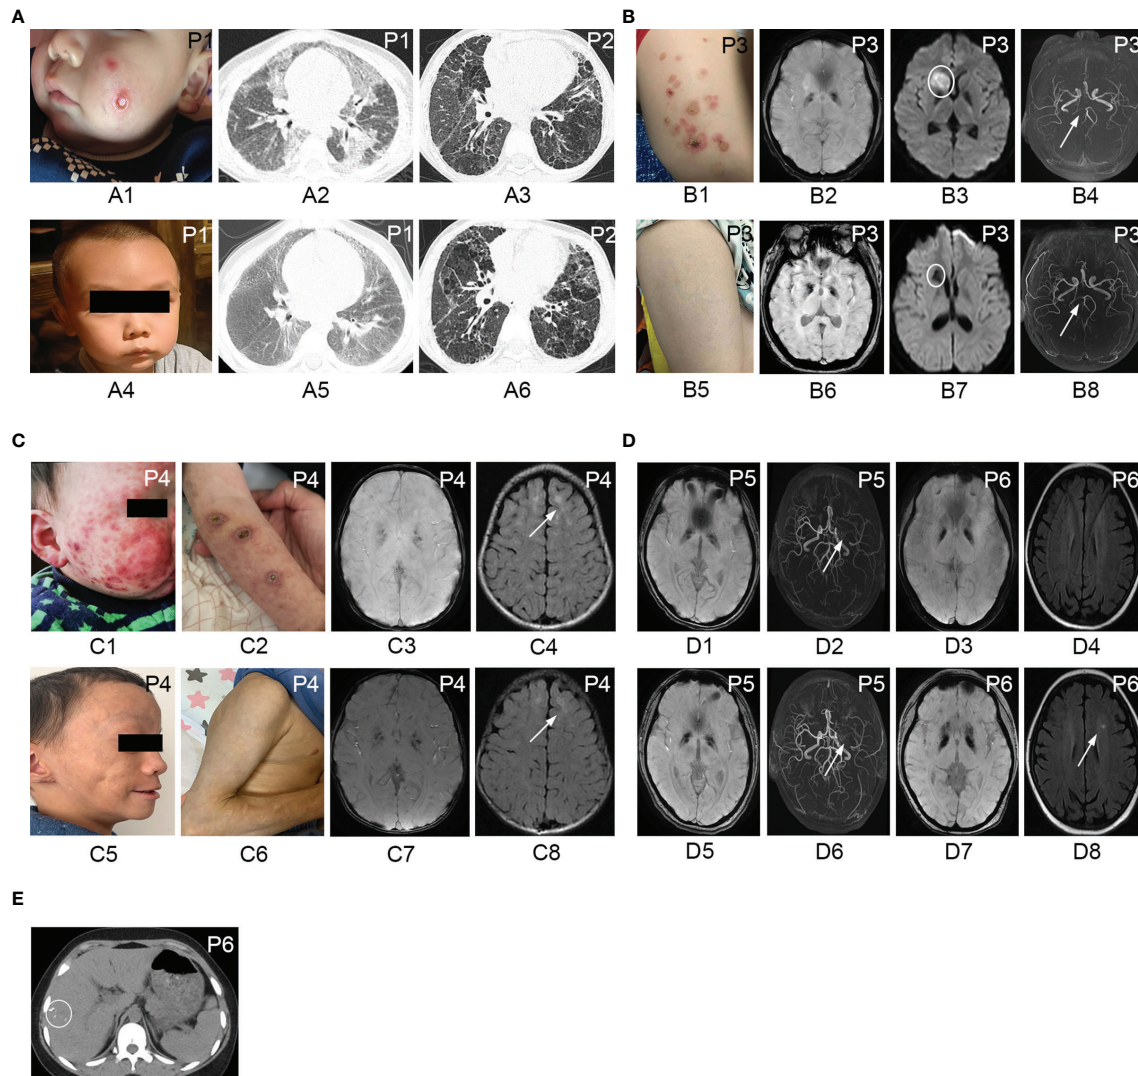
Cutaneous manifestations, chest CT, and brain MRI of patients with IFNopathies before and after the treatment with jakinibs. Chilblain-like lesions and ulcerations on the cheek of patient 1 (A1) disappeared after the treatment with ruxolitinib (A4). Chest CT scan of patient 1 demonstrating diffuse cords, patchy consolidation, and ground-glass opacities (A2) before the treatment, which improved after the treatment (A5). Chest CT scan showing no significant improvement of reticular opacities, ground-glass opacities, and cysts in patient 2 before (A3) and after (A6) the treatment with tofacitinib. Erythematous rashes on the left leg of patient 3 (B1) resolved after the treatment with ruxolitinib (B5). Susceptibility weighted imaging showing symmetric hypointense signal in the basal ganglia region in patient 3 (B2), patient 4 (C3), patient 5 (D1), and patient 6 (D3) corresponding to calcification areas in brain CT scan and no improvement observed after the treatment (B6, C7, D5, D7). Diffusion weighted imaging showing hyperintensity in the right head of the caudate nucleus and right anterior limb of the internal capsule (B3) in patient 3. Repeated MRI showing hypointense signal in diffusion weighted imaging (B7) indicating encephalomalacia after the treatment. Brain magnetic resonance angiography indicating stenosis and occlusion of the posterior cerebral artery (B4) in patient 3 and recanalization after the treatment (B8). Erythematous rashes, chilblain-like lesions, ulcerations on the cheeks, and the arm of patient 4 (C1, C2) disappeared after the treatment with ruxolitinib, left with subcutaneous lipomatous (C5, C6). T2 FLAIR MRI showing hyperintensity in the bilateral frontal lobe in patient 4 (C4) and no improvement after the treatment with ruxolitinib (C8). Brain magnetic resonance angiography revealing occlusion of the left middle cerebral artery with the formation of peripheral collateral circulation with no changes before (D2) and after the treatment (D6) in patient 5. T2-weighted MRI of patient 6 demonstrating hyperintensity in the left corona radiata (D8) after treatment with tofacitinib which was not observed before the treatment (D4). Abdominal CT scan showing multiple calcifications in the liver in patient 6 (E). P, patient.
